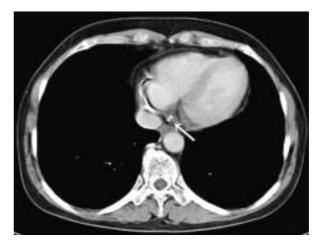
Transverse multi-detector computed tomography scan showing coronary artery calcification (*arrow*)in the right coronary artery
